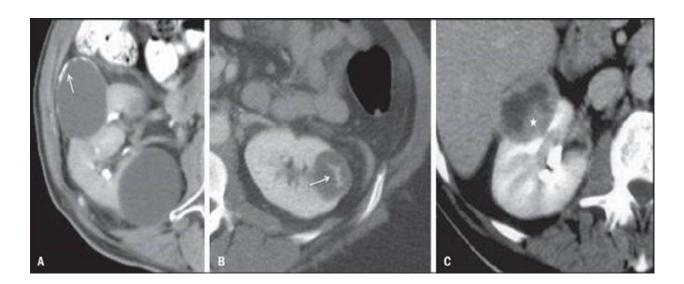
A: Categories I and II. Contrast-enhanced, axial CT section demonstrates a cyst with smooth and imperceptible walls, category I, and another with fine calcifications on its walls (arrow), category II, both without perceptible contrast-enhancement. B: Category III. Contrast-enhanced axial CT section demonstrates a cyst with smooth walls and a thin septum with perceptible and measurable
